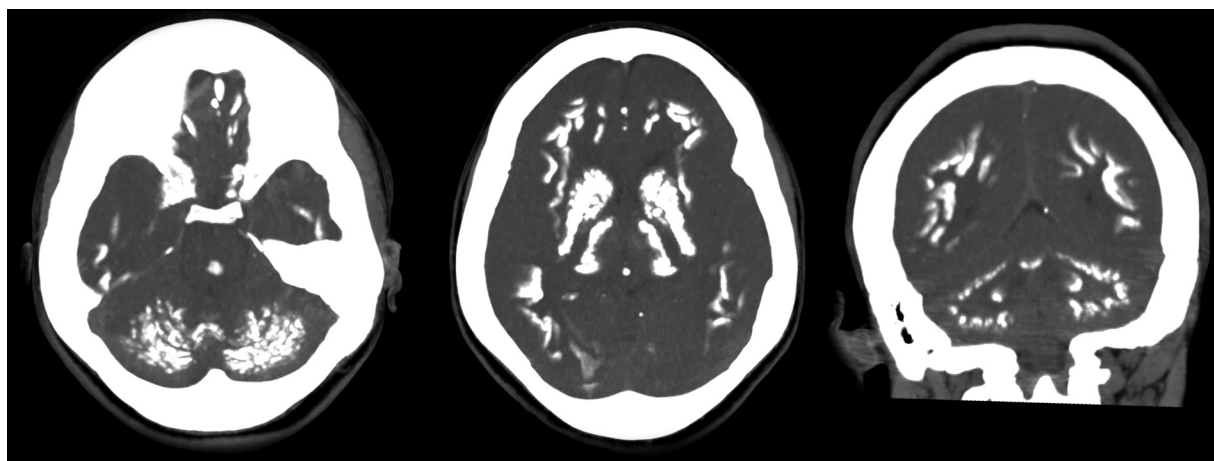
Brain CT scan disclosing bilateral and symmetrical calcification in the basal ganglia, thalamus, dentate nuclei, and subcortical white matter.
